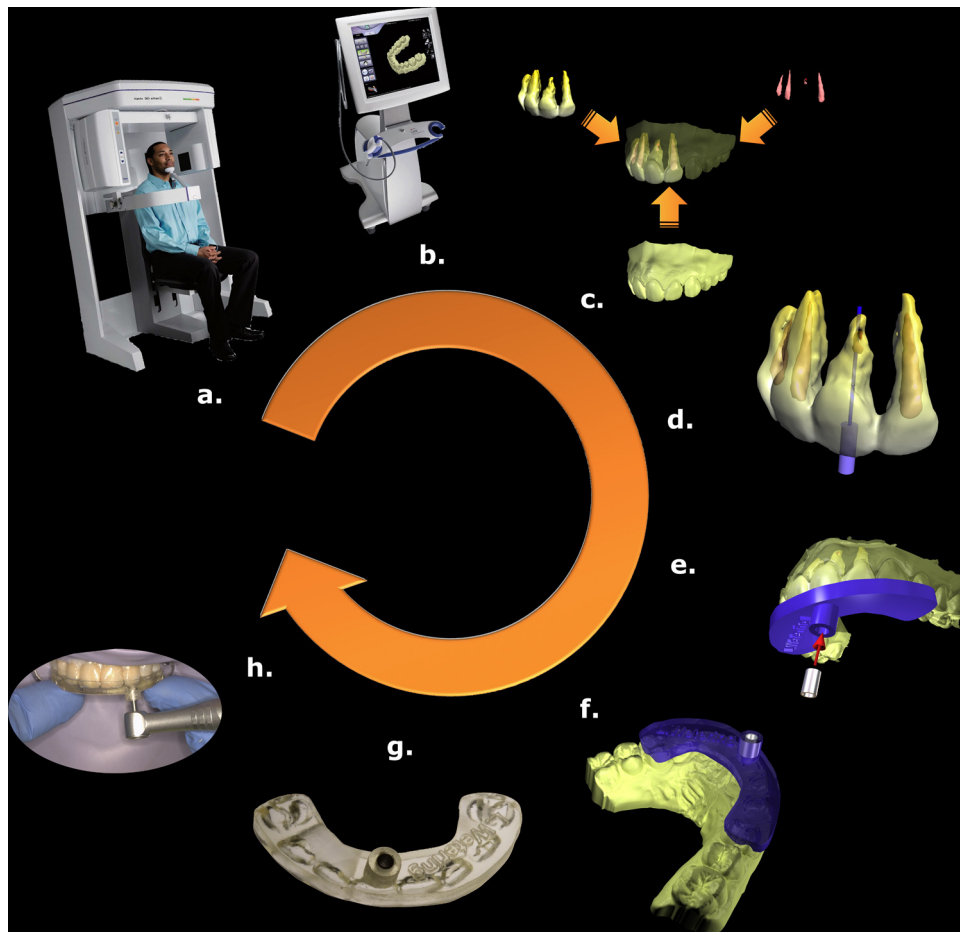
An overview of the 3D planning for the endodontic directional guide and its application in the patient. A cone-beam CT is made (a) of the teeth involved in the planning. An impression of the dentition is made with an intra-oral scanner (b). In GOM inspect software the datasets of the teeth, pulp, bone and digital impression are registered (c). In 3D software the planning of the direction of the access is made (d) and a guide is designed with space dedicated for the metal guiding sleeve (e). When the final design is ready (f), it can be sent to a dental lab or a rapid prototyping facility. The printed guide (g) for use in the mouth of the patient (h). With this guide the root canal system is identified and prepared.
